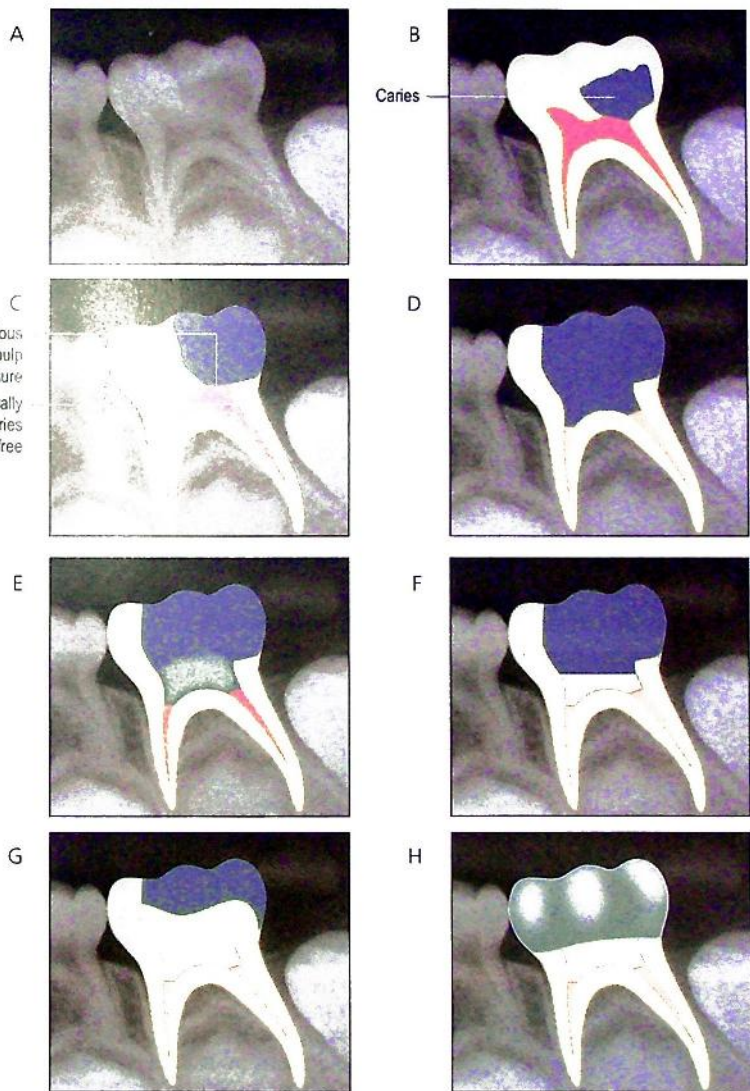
Method of performing a pulpotomy. (A) Preoperative radiograph shows deep carious lesion. Clinical history revealed intermittent symptoms on eating with no history of spontaneous pain. (B) Carious lesion identified relative to dental anatomy. (C) Cavity preparation showing complete removal of peripheral caries. (D) After the tooth is rendered free of caries, the roof of the pulp chamber is removed completely, and the pulp is amputated to the level of the pulpal floor. Haemostasis must be achieved at this point before proceeding. (E) The therapeutic agent is applied to the pulpotomy site. (F) Base is applied to completely seal the pulpotomy site. (G) The tooth is built up with a core material. (H) The tooth is restored with a preformed metal crown.
